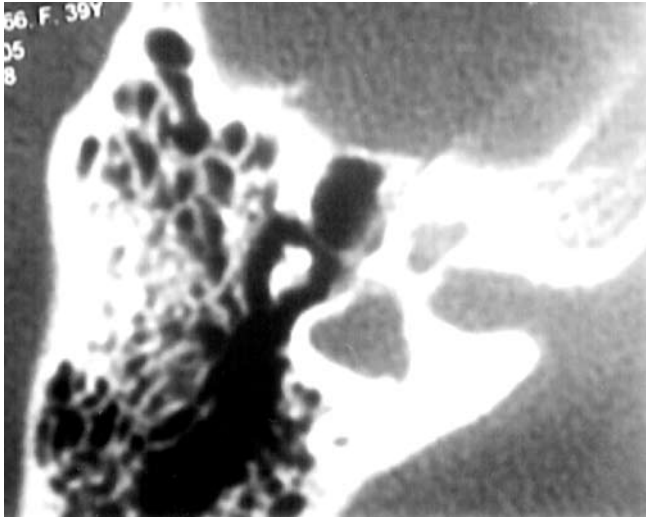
Axial CT section of right ear showing LSC-vestibule dysplasia (Type B-1 malformation).
